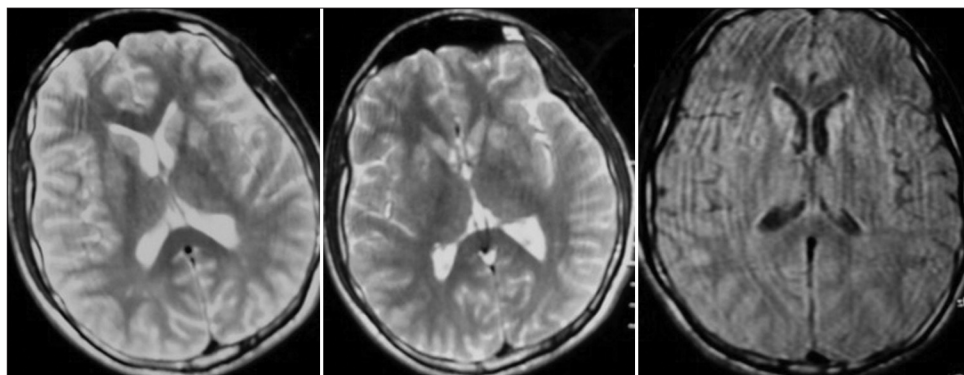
Axial T2-weighted and FLAIR MRI showed asymmetrical nonspecific signals on basal ganglia
